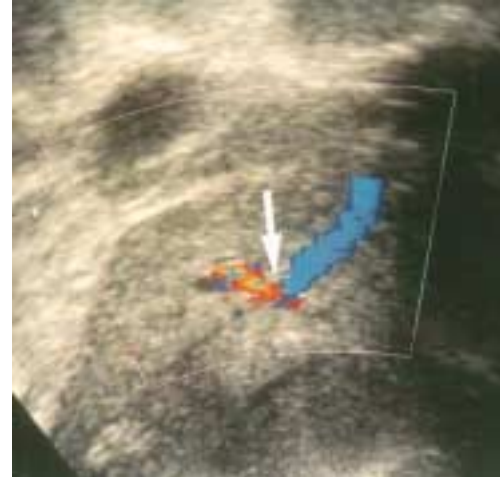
Longitudinal colour Doppler sonogram demonstrating arteriovenous fistula (arrow)
